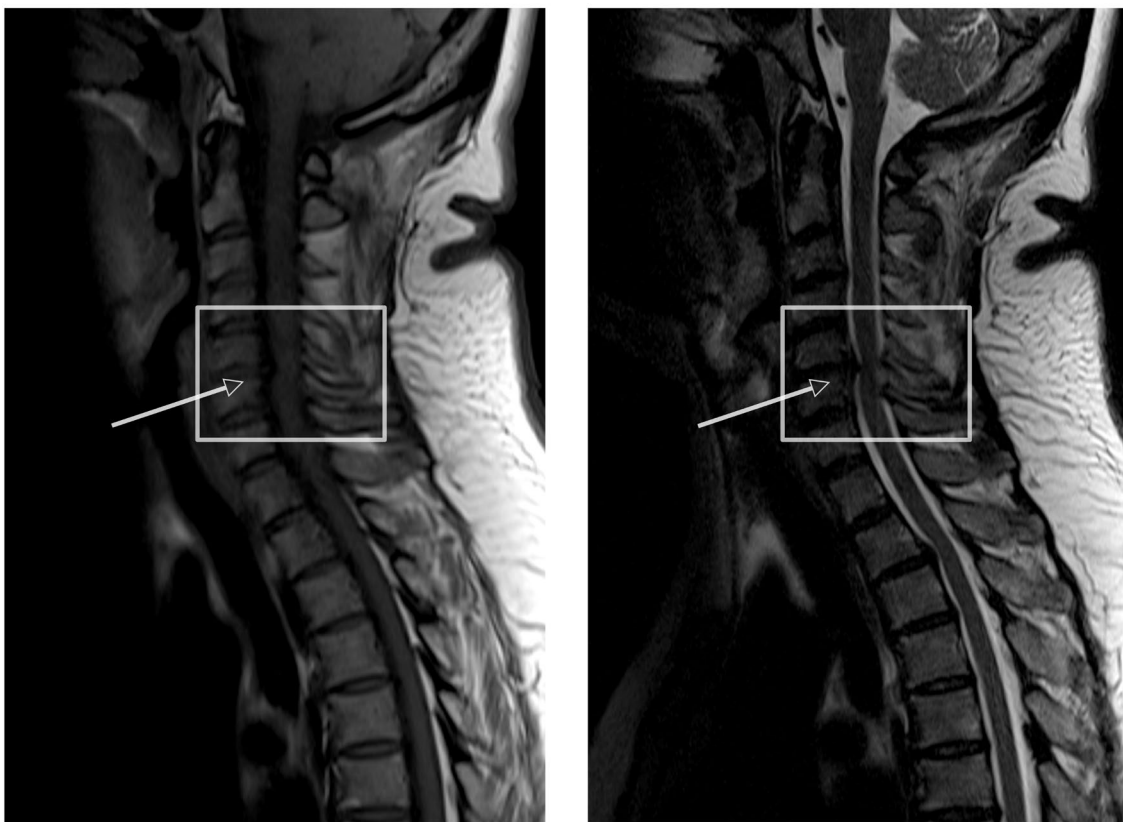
Cervical spinal stenosis in magnetic resonance imaging. The T1-weighted (left) and T2-weighted (right) images show spinal cord compression mainly caused by a disc protrusion at the level between cervical vertebra (CV) 5 and 6.
